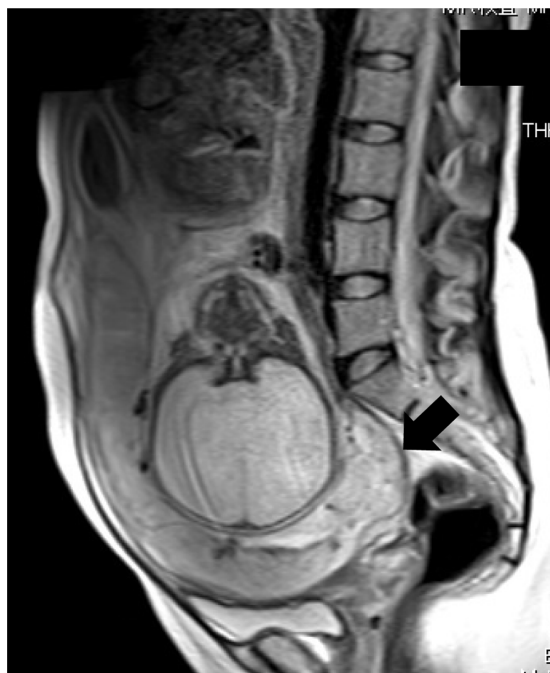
MRI image of the abdomen.
